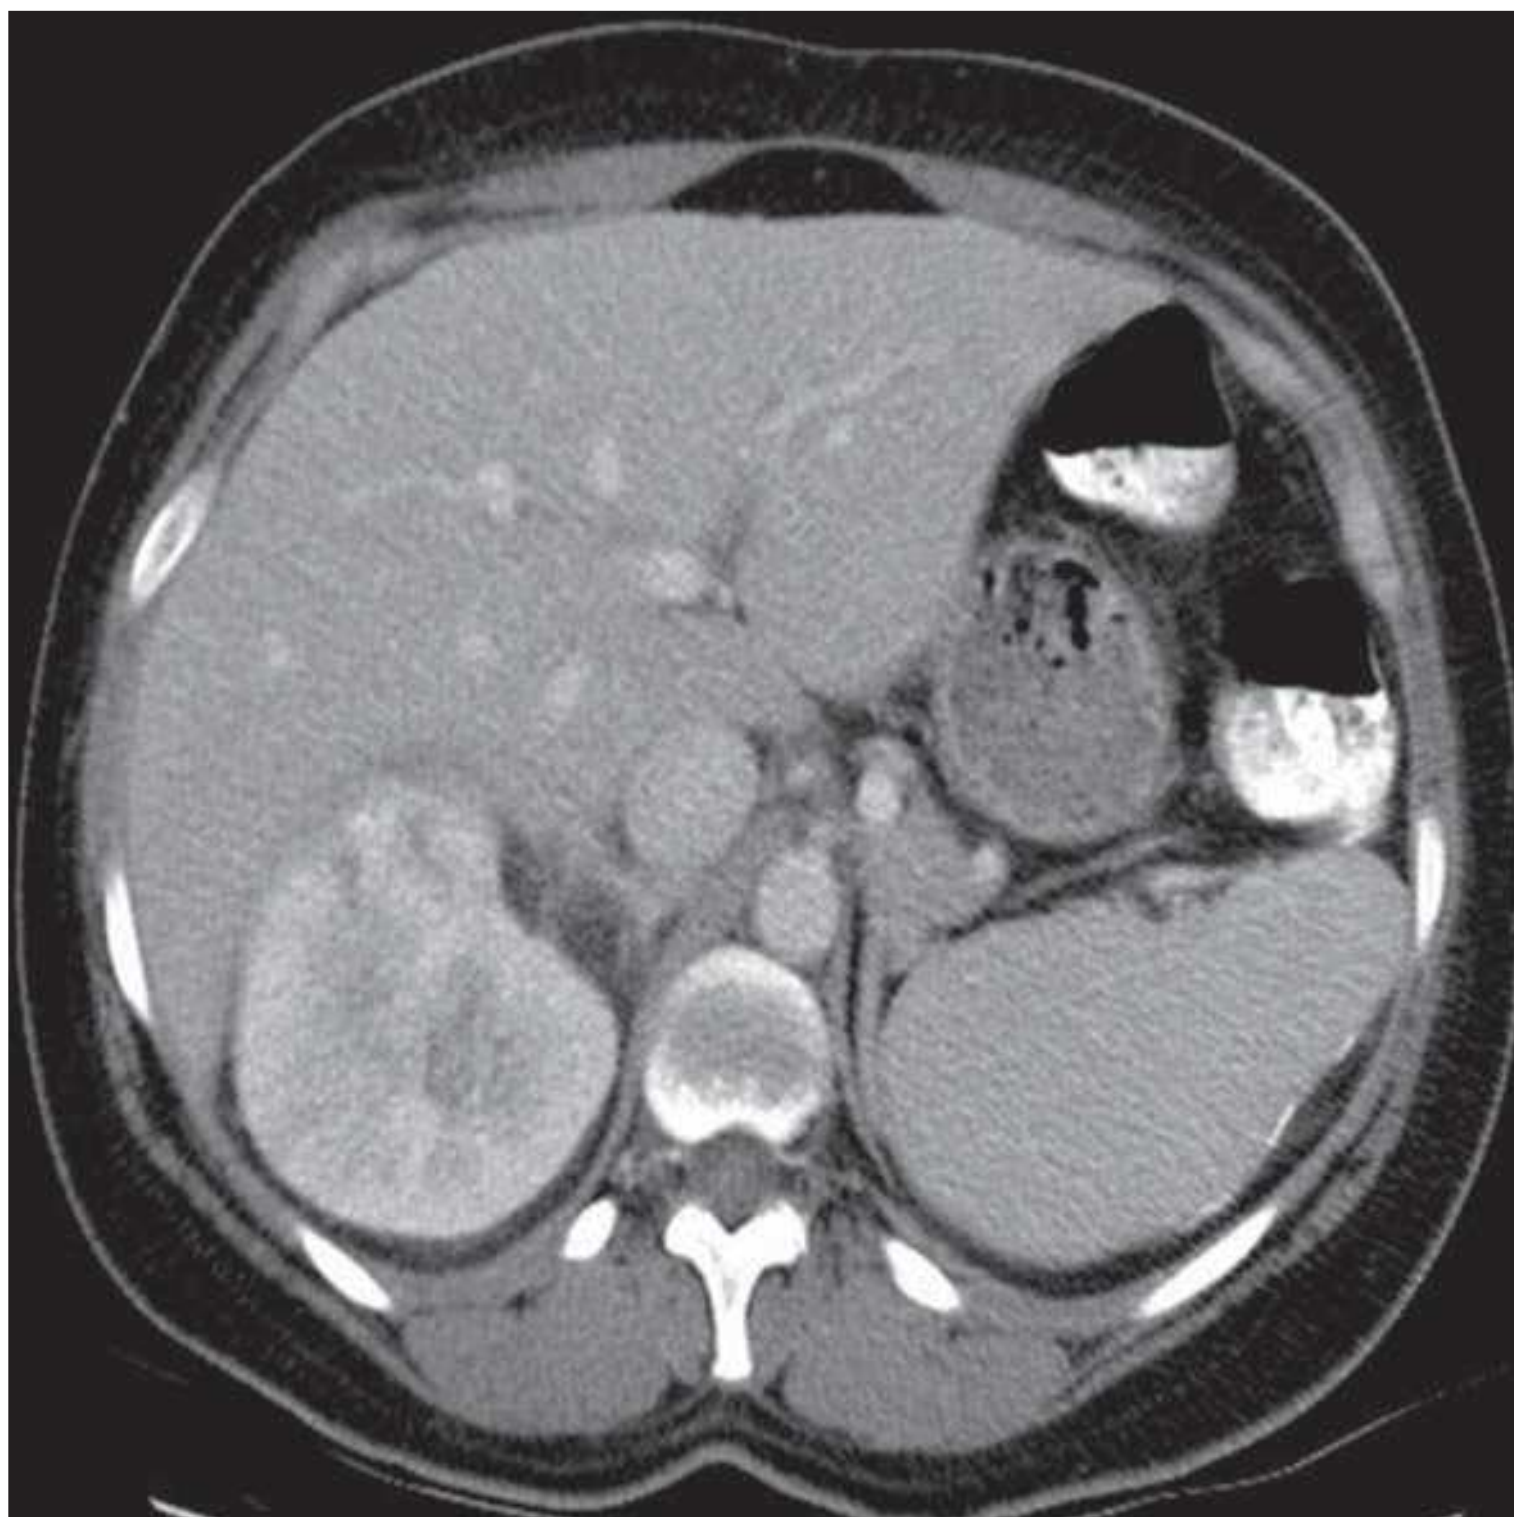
Contrast-enhanced CT in a patient with clinical symptoms of acute pyelonephritis showing striated nephrogram in an edematous right kidney with multiple linear non-enhancing areas.
